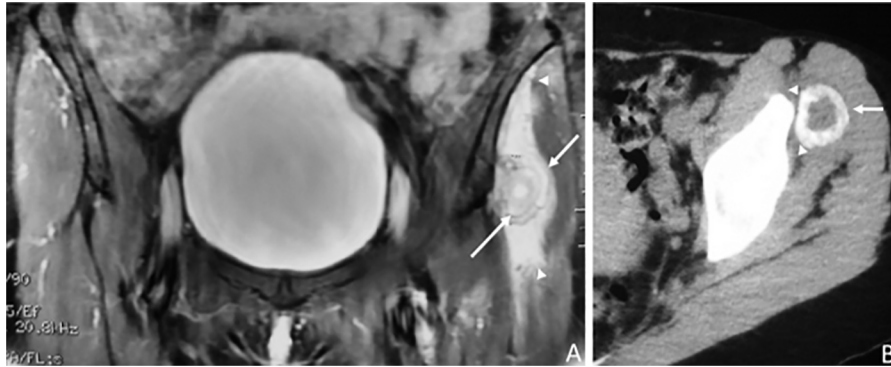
A 42-year-old woman with a palpable mass in the left gluteal region. After questioning she recalled an injury at the gym about six weeks ago. The diagnosis of MO was confirmed by CT findings. (A) A coronal fat-suppressed contrast enhanced T1w MR image shows concentric hyperintense rings (arrows) within the mass and extensive oedema of the surrounding muscle (arrowheads). (B) An axial CT image shows a typical MO lesion with thick calcified rim (arrow) surrounding a mildly hypodense centre. A thin line separates the myositis ossificans lesion from ileac bone (arrowheads) the so-called 'string' sign.
